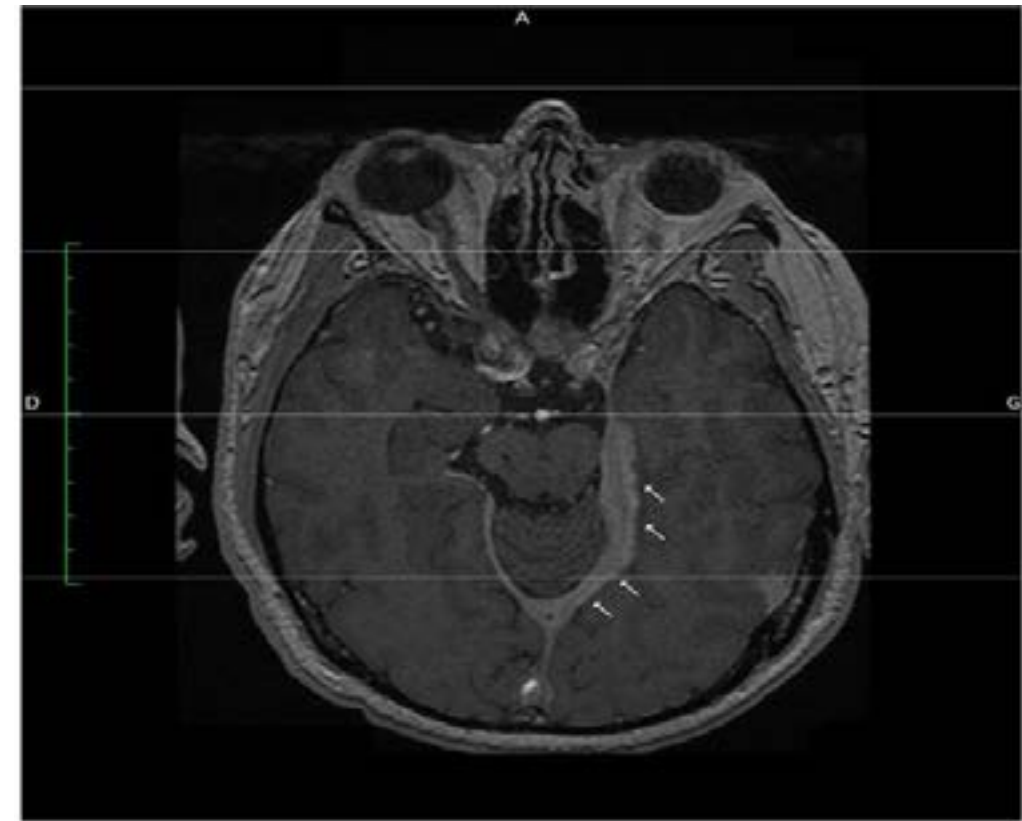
MRI T1 axial image showing thickening of the left cerebellar tentorium.
